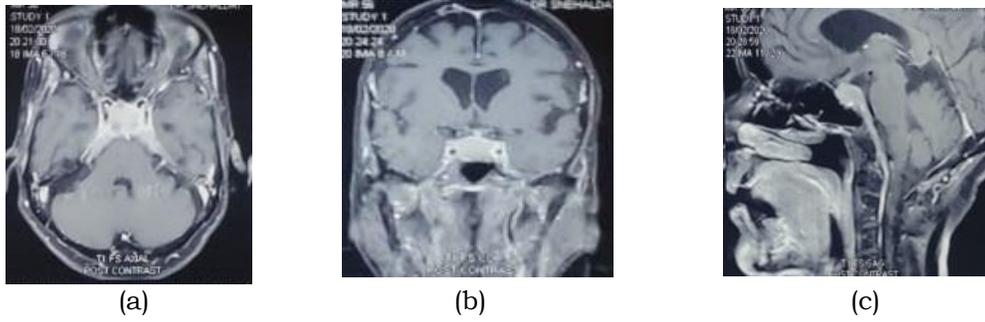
Axial (a), coronal (b), and sagittal (c) views of T1 contrast MRI Brain (Feb 2020)
